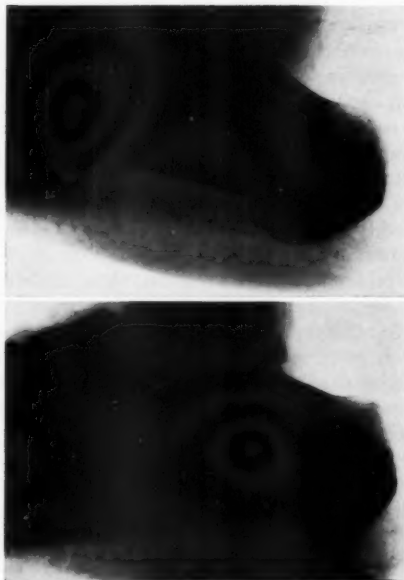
Structure of the heel pad as revealed by radiograph. Top, without weight-bearing, bottom, patient standing.
